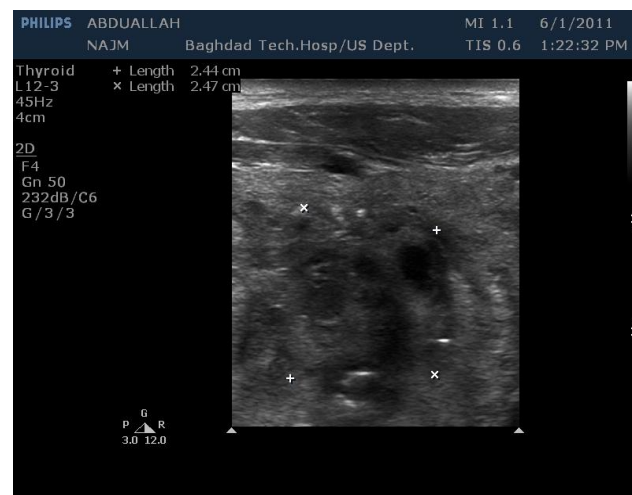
Longitudinal sonogram of a papillary carcinoma with coarse calcifications.
